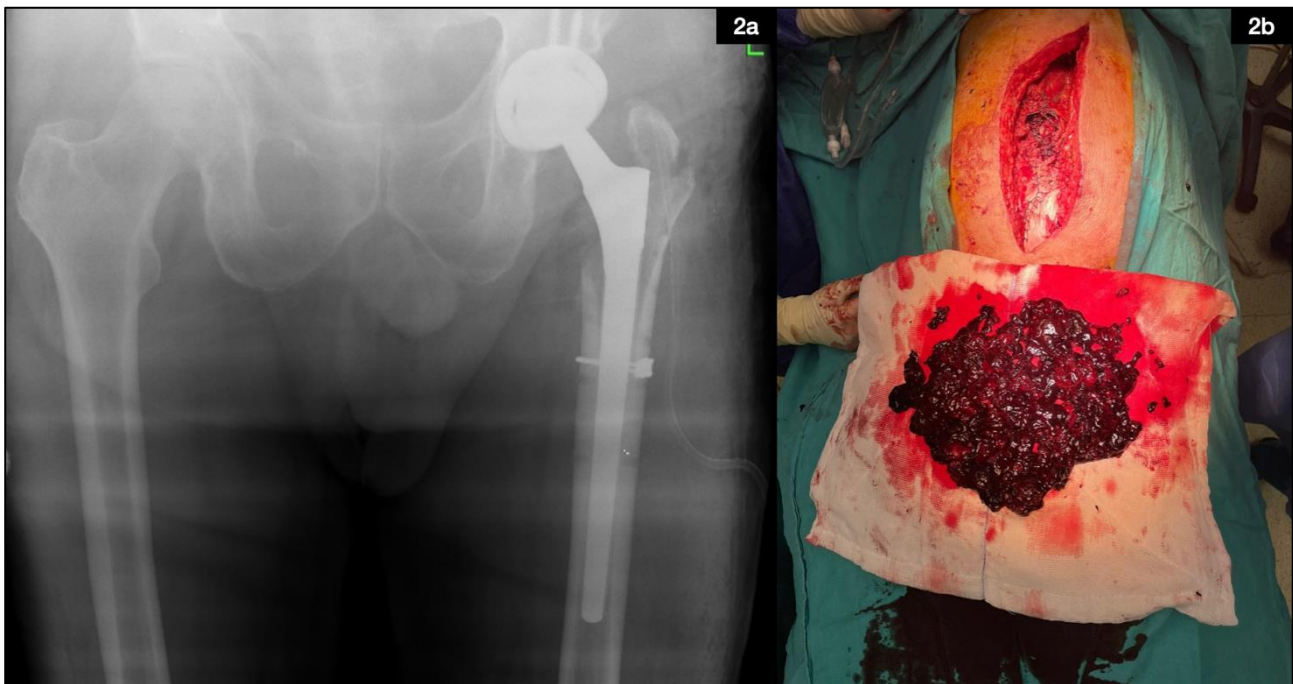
Postoperative imaging and procedures for total hip prosthesis, including X-ray showing a cable at the diaphysis level (2a) and hematoma evacuation after revision total hip arthroplasty (2b).
